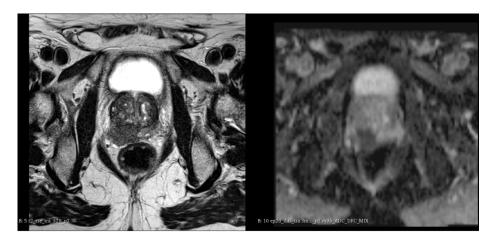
Example of prostate mp-MRI images. Left: T2w; Right: ADC. Please note that slices are different in the 2 maps
